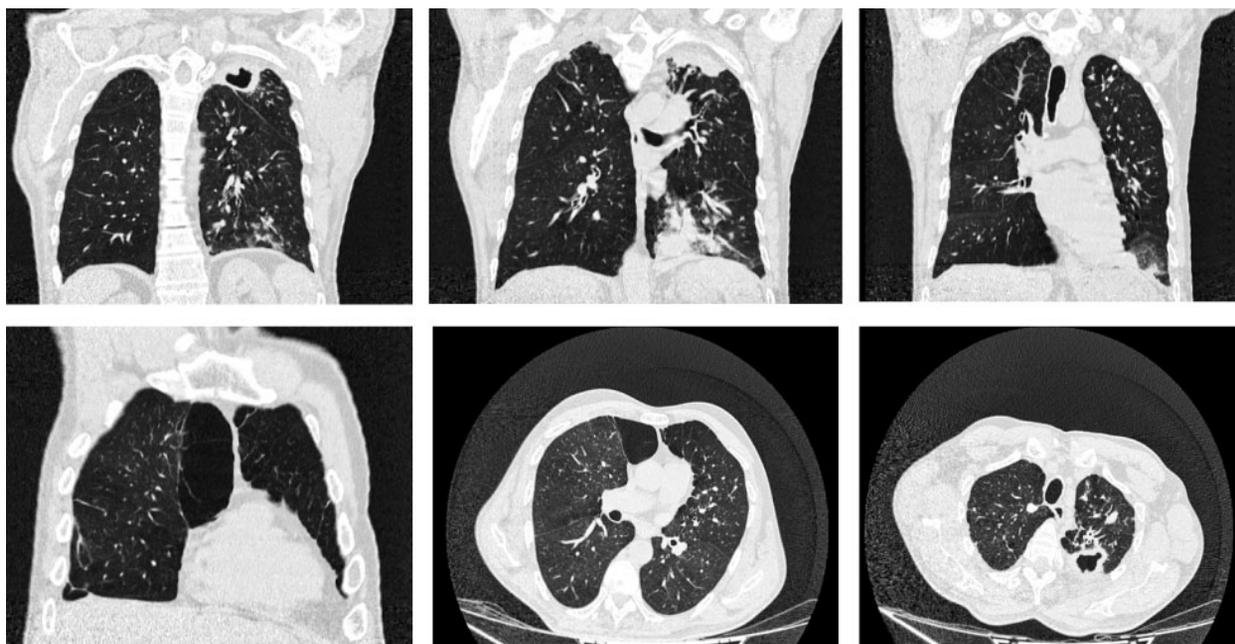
CT scan of the thoracic cavity dated 3 September 2019
